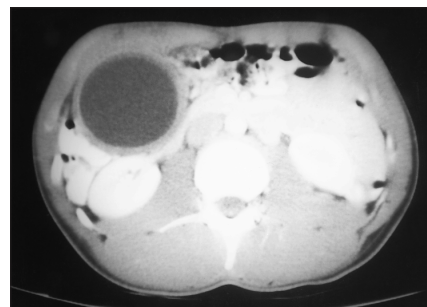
Computed tomography scan showing cystic lesion.
